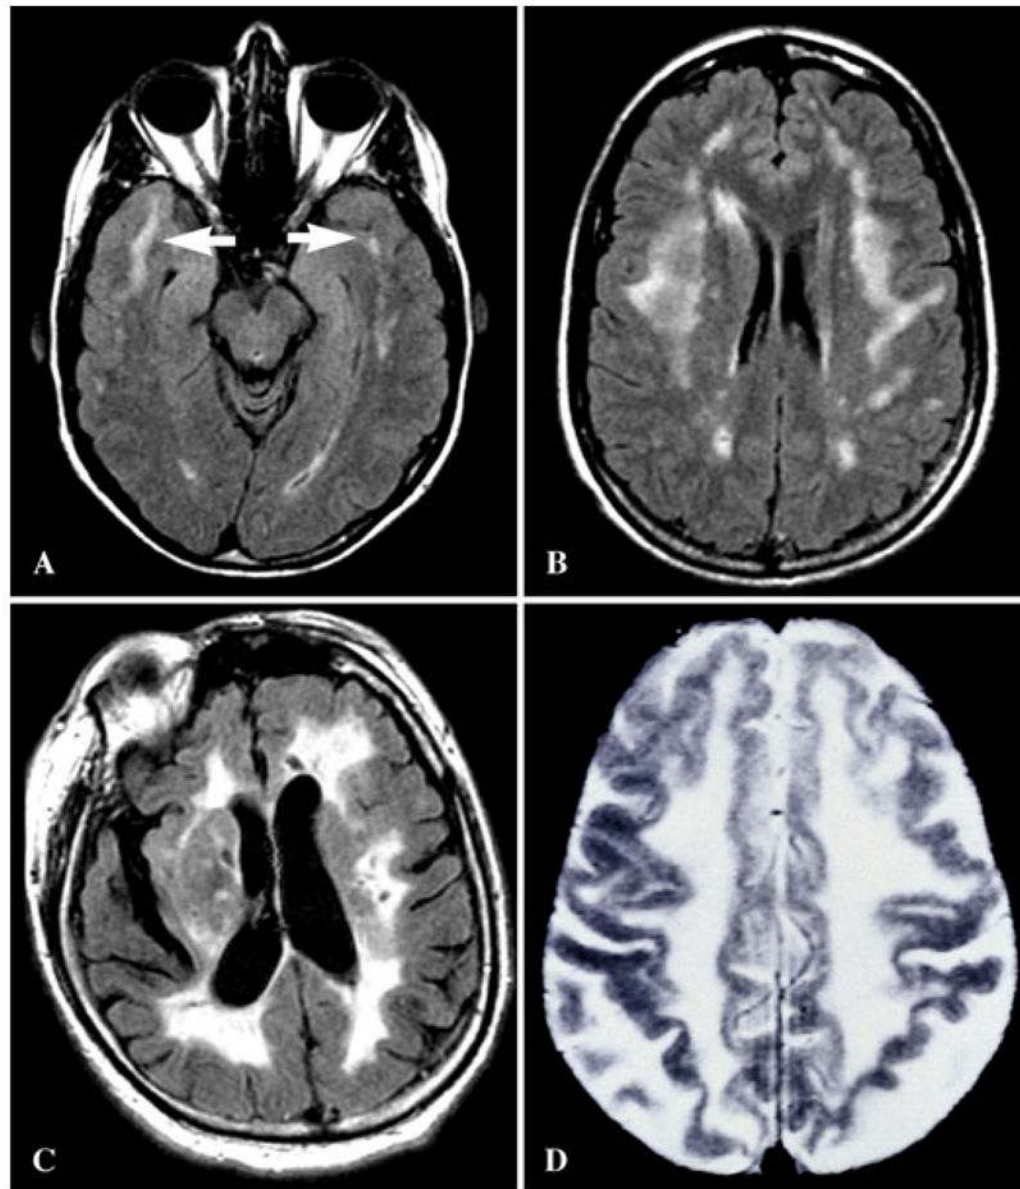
MRI appearance of white matter changes in axial sections of patients with CADASIL. (A, B) FLAIR MRI in an asymptomatic 39-year-old, notch 3 gene positive with family history of early stroke, whose imaging findings were incidentally noted. Characteristic temporal lobe white matter involvement is highlighted (*arrows*). (C) FLAIR MRI in a patient with clinically established CADASIL. (D) T2-weighted MRI in a patient with notch 3 gene and pathologically proven disease.
